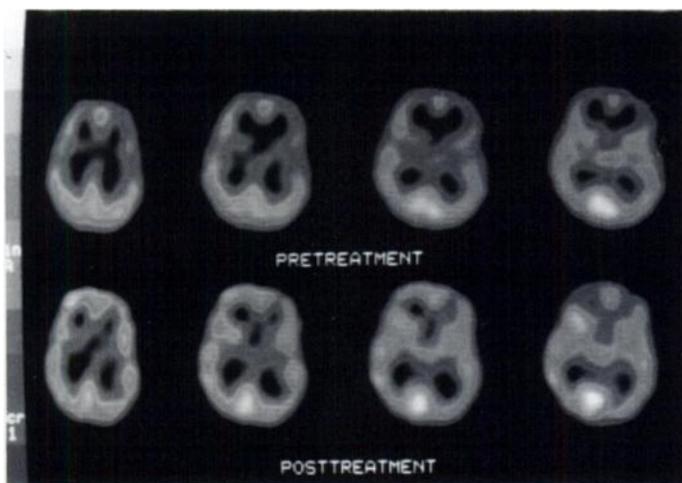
Upper row: pretreatment SPECT study; four sequential transaxial consecutive slices of Patient 2 show hypoperfusion in the same regions as in Patient 1. Lower row: post-treatment SPECT study of the same patient shows that cortical perfusion is normal.
